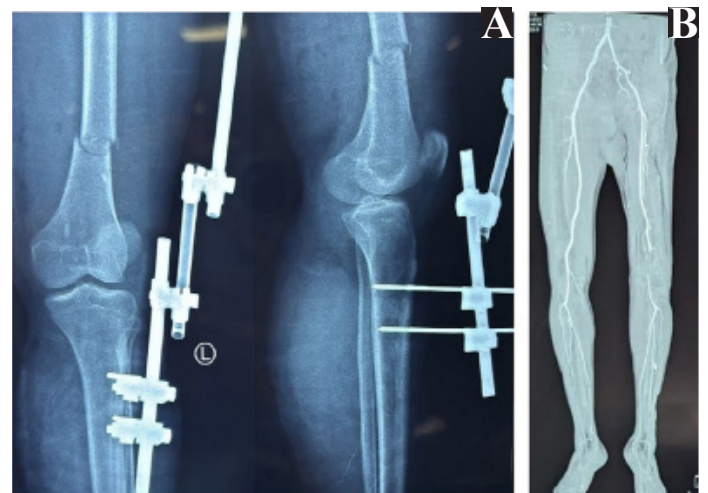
A. X-ray of the left thigh with knee showing a shaft of femur fracture with external fixator in situ; B. CT angiography of the left lower limb showing segmental cut-off of the superficial femoral artery
